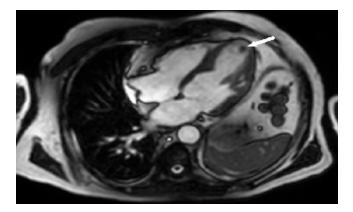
Cine MRI demonstrating a small apical thrombus (arrow)
